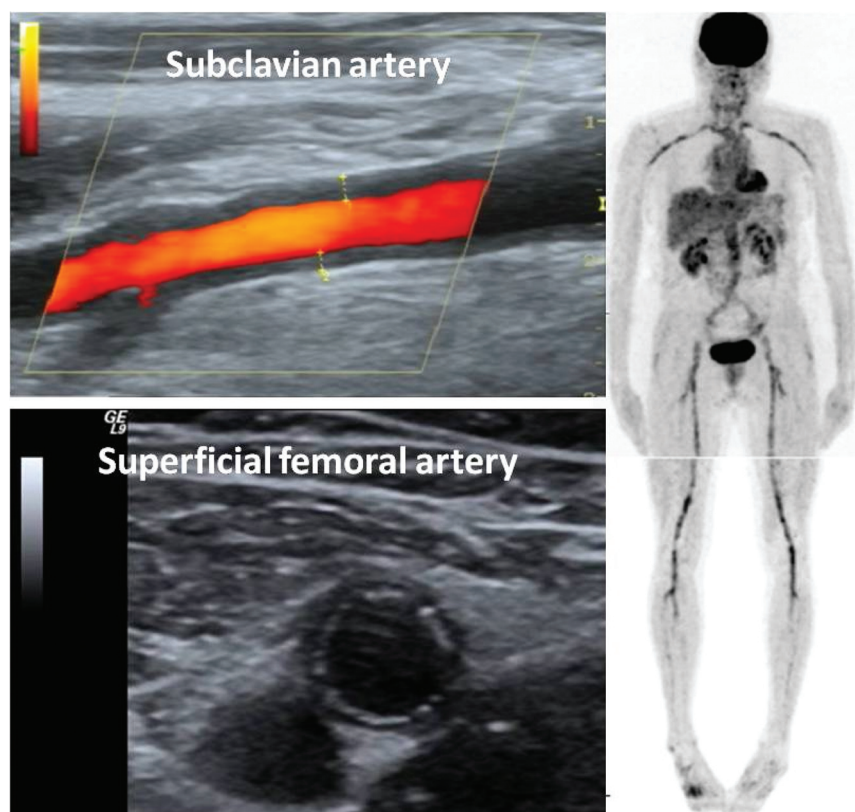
Vascular inflammation (18-FDG-PET) and hypoechoic wall thickening (CDS) of the extremity arteries related to LV-GCA in a 59-year-old woman with FUO
